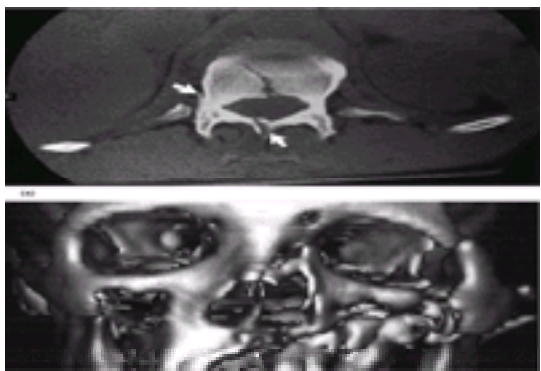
(a) High resolution CT image obtained in a patient with rotational injury at the thoracolumbar junction. There is a sagittal fracture of the vertebral body. Note that high resolution display also reveals fractures of the neural arch and base of the right pedicle (arrows). (b) Three-dimensional reconstruction produced by surface rendering of CT data in a patient with a comminuted left orbitomaxillary fracture (reproduced by courtesy of Mr S.R. Watt-Smith).
